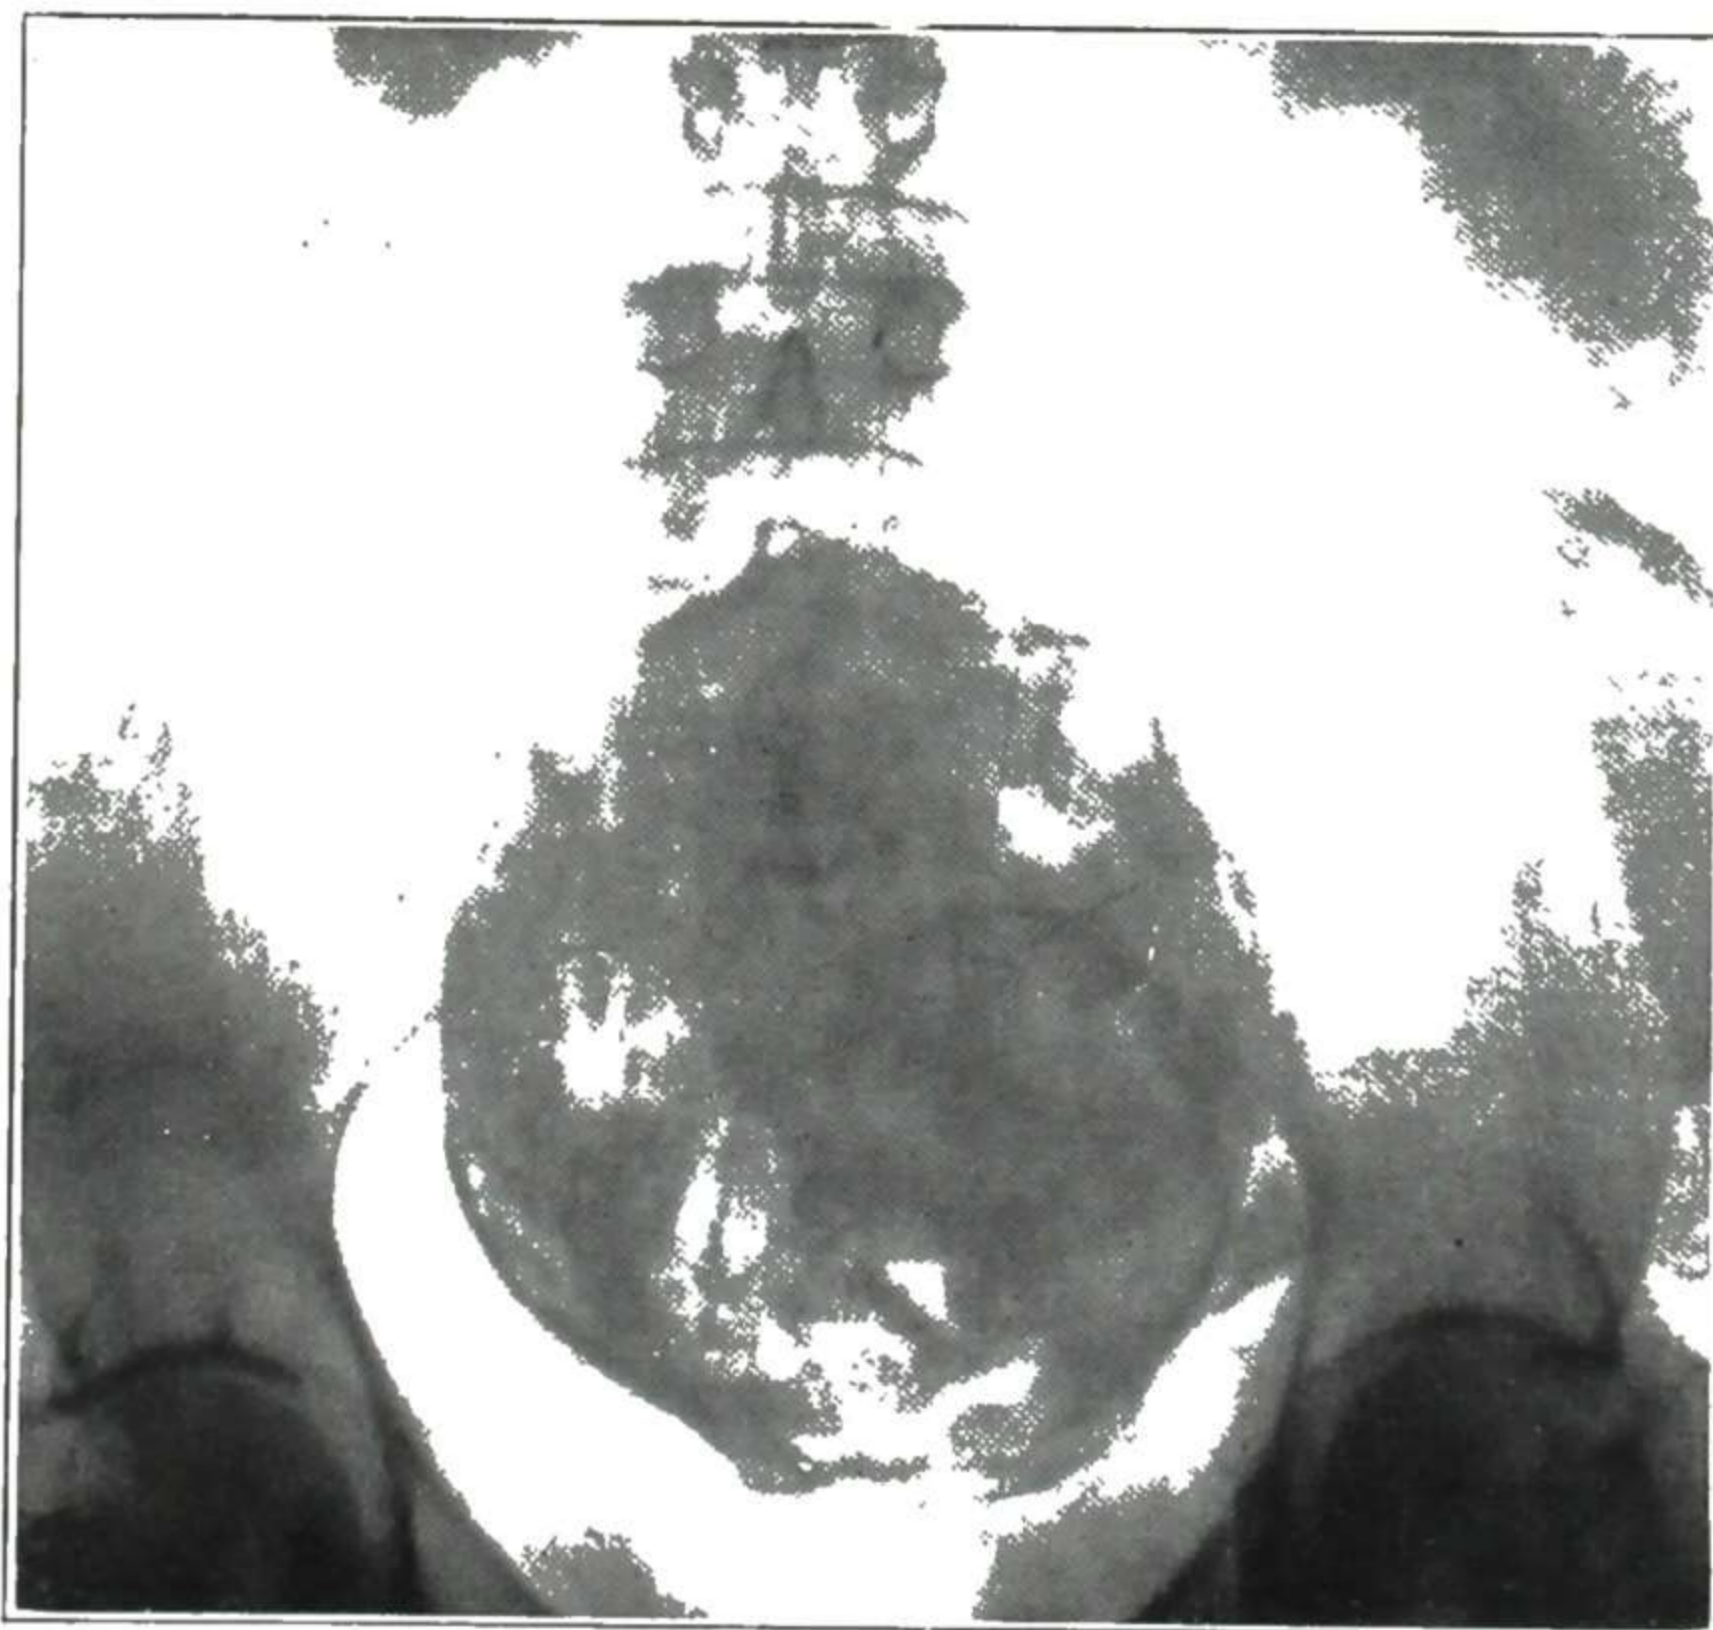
X-ray of a calcified tumor mass containing fetal bones. This was an eight months' extrauterine pregnancy, calcified and retained for forty years. (From Titus and Eisaman: *Am. J. Obst. & Gynec.*)
